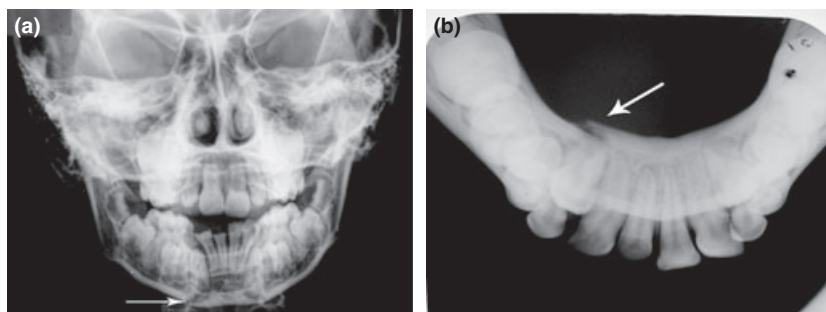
(a) PA mandible radiograph showing right parasymphysis fracture. (b) Occlusal radiograph showing lingual aspect of fracture.
